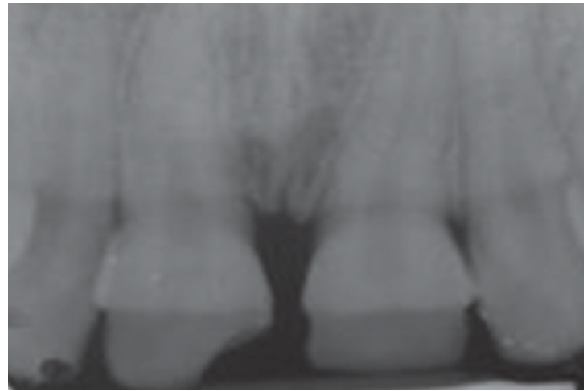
Preoperative intraoral periapical radiograph showing reduced enamel thickness in the central incisors due to enamel hypoplasia from a history of trauma (Gupta et al., 2014).
